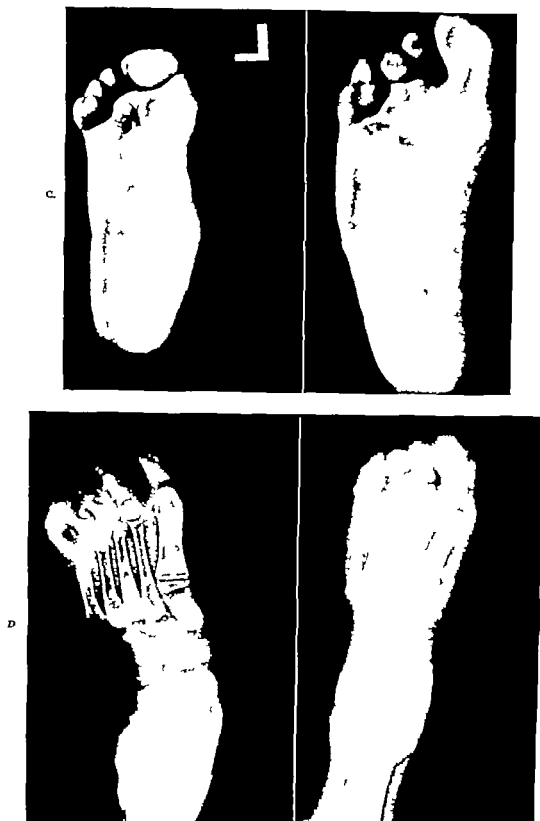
(cont'd) C. Photographs showing preoperative and postoperative plantar views. D. Preoperative and postoperative anteroposterior roentgenograms. Note relative metatarsal adduction; preoperative view—more apparent in postoperative view.
